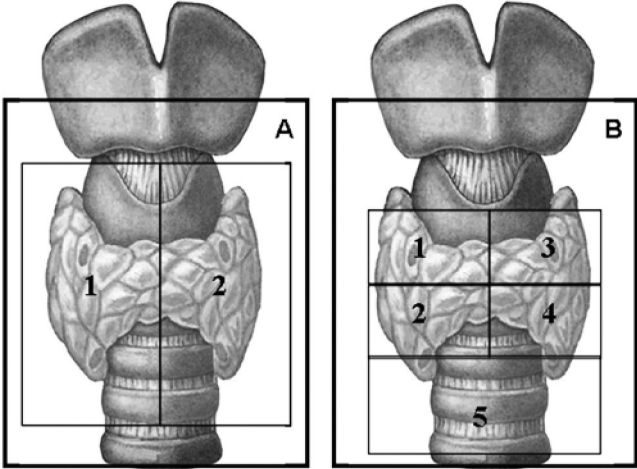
Analysis of the ability of Tc99m-MIBI-SPECT scan to correctly localize a pathological parathyroid gland as confirmed by localization at surgery by dividing the neck into 2 anatomical areas (the right and left side of the neck) (A) or into 5 anatomical areas (the four thyroid quadrants and a 5th area of all possible ectopic localizations in the mediastinum) (B).
